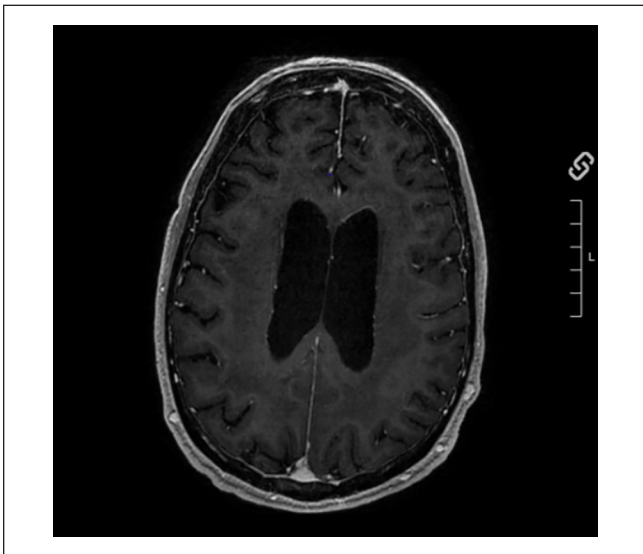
Magnetic resonance imaging of the brain 2 months after treatment with ibrutinib showing complete resolution of previously noticed white matter enhancements.
